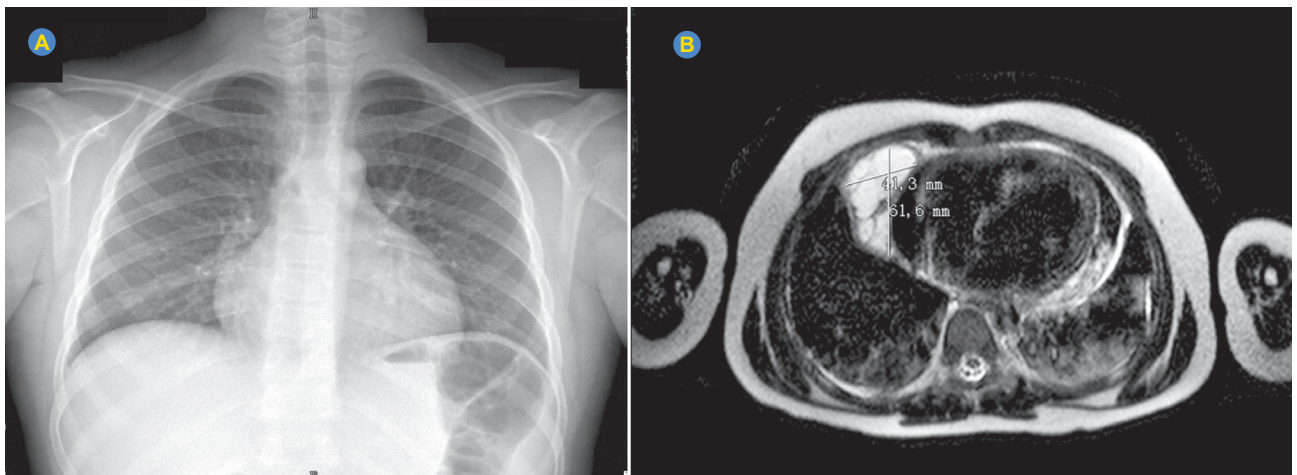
Enlargement of the mediastinum in the chest radiography (A). MRI showing pericardial cyst in the right hemithorax, measuring 61.6 x 41.3 mm (B).
